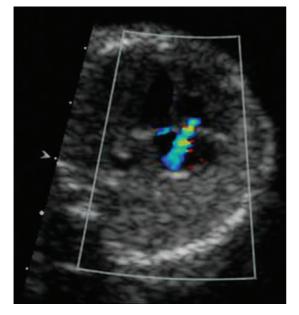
Ultrasound of fetal heart showing tricuspid regurgitation.
